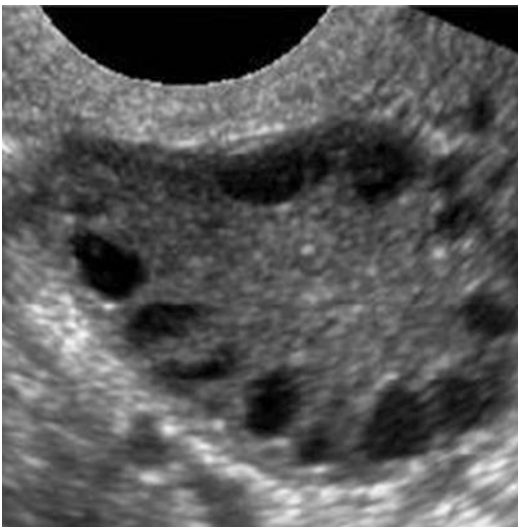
PCOS ultrasound study (note the peripheral small cysts, “string of pearls”)
